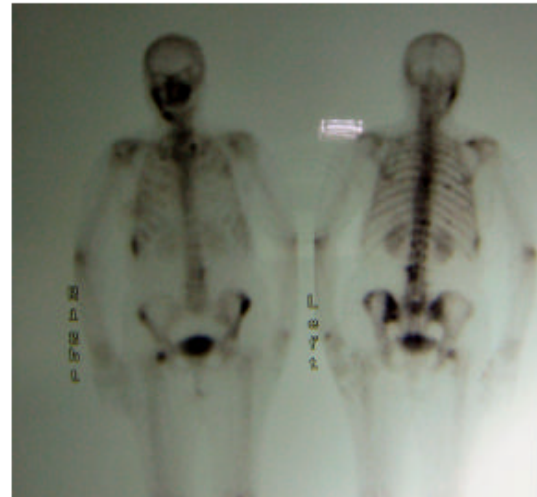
Bone scintigram shows a hot spot on the right side of the mandible
